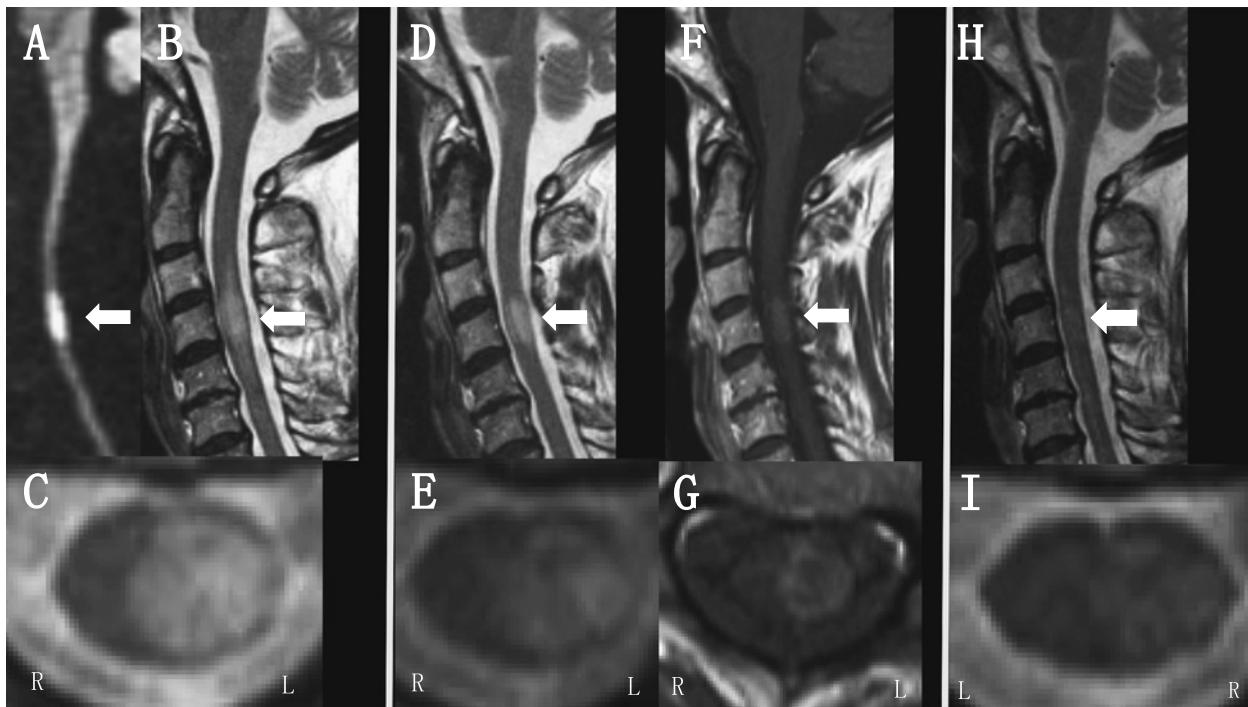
Cervical spine MRI findings.
